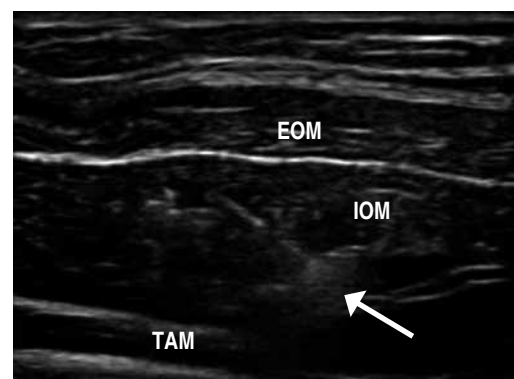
Ultrasound of the muscles of the lateral component at the flank level: external oblique muscle (EOM). Internal oblique muscle (IOM). Transverse muscle (TAM). The arrow shows the needle entry during transverse plane block. Ropi: lake of local anesthetic (ropivacaine) while it is infiltrated between TAM and IOM.
